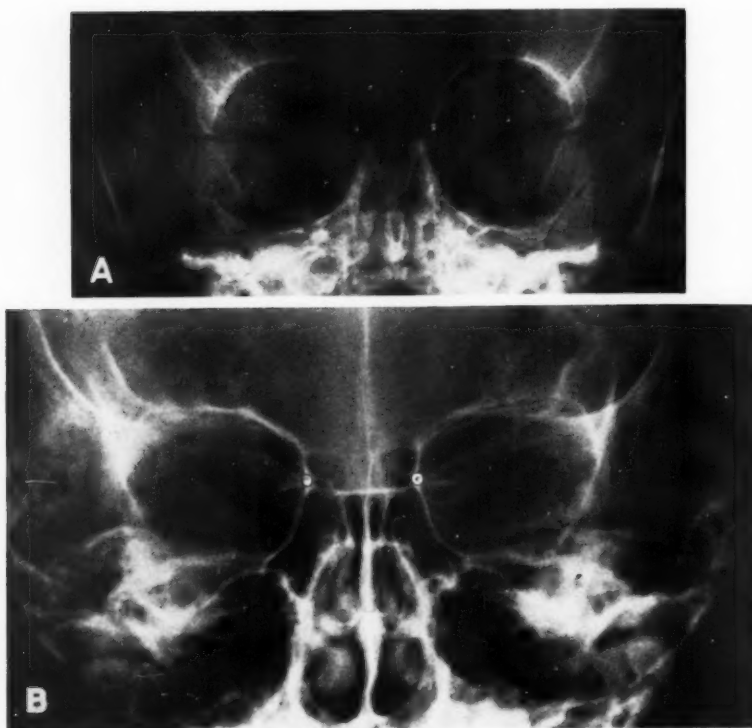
Postero-anterior roentgen projection of the skull of a normal infant aged one week (A), and of the skull of a normal child aged seven years (B). The white dots indicate the points chosen to measure the interorbital distance for this study.
